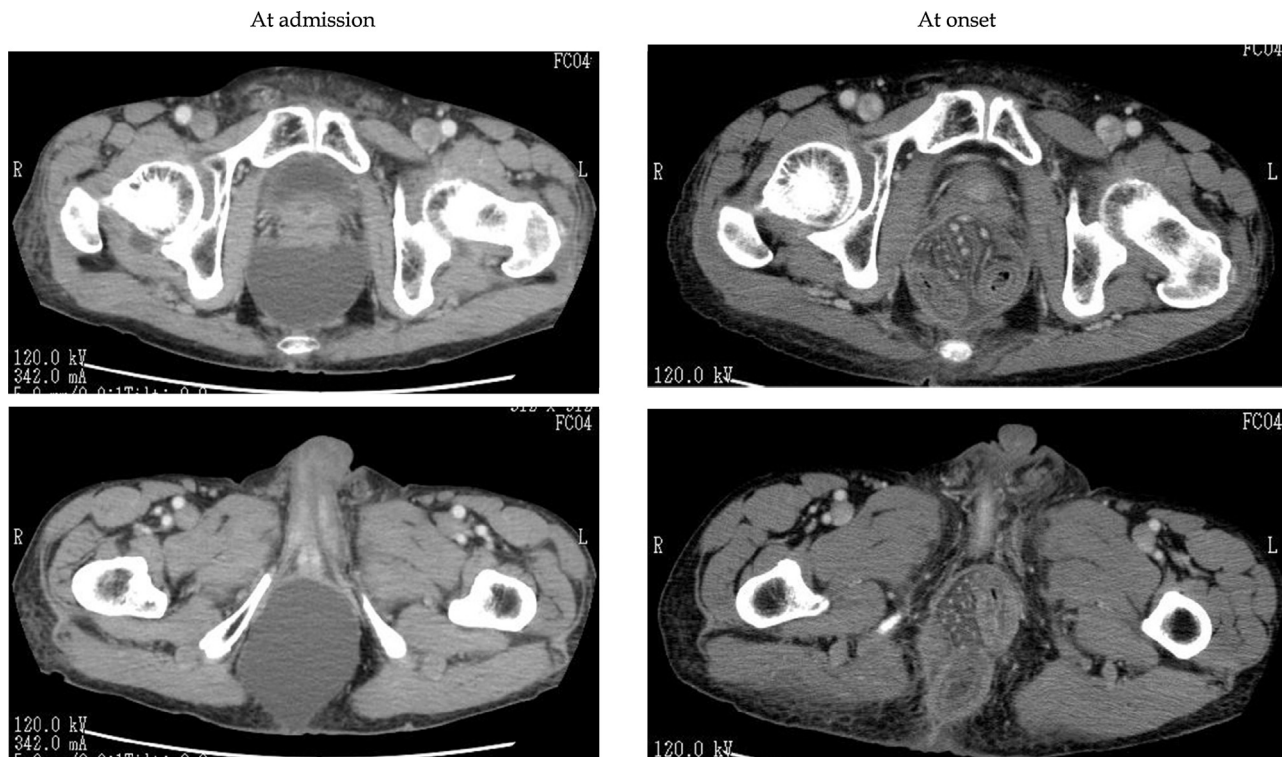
Computed tomography image of the pelvis demonstrating a strangulated perineal hernia.
